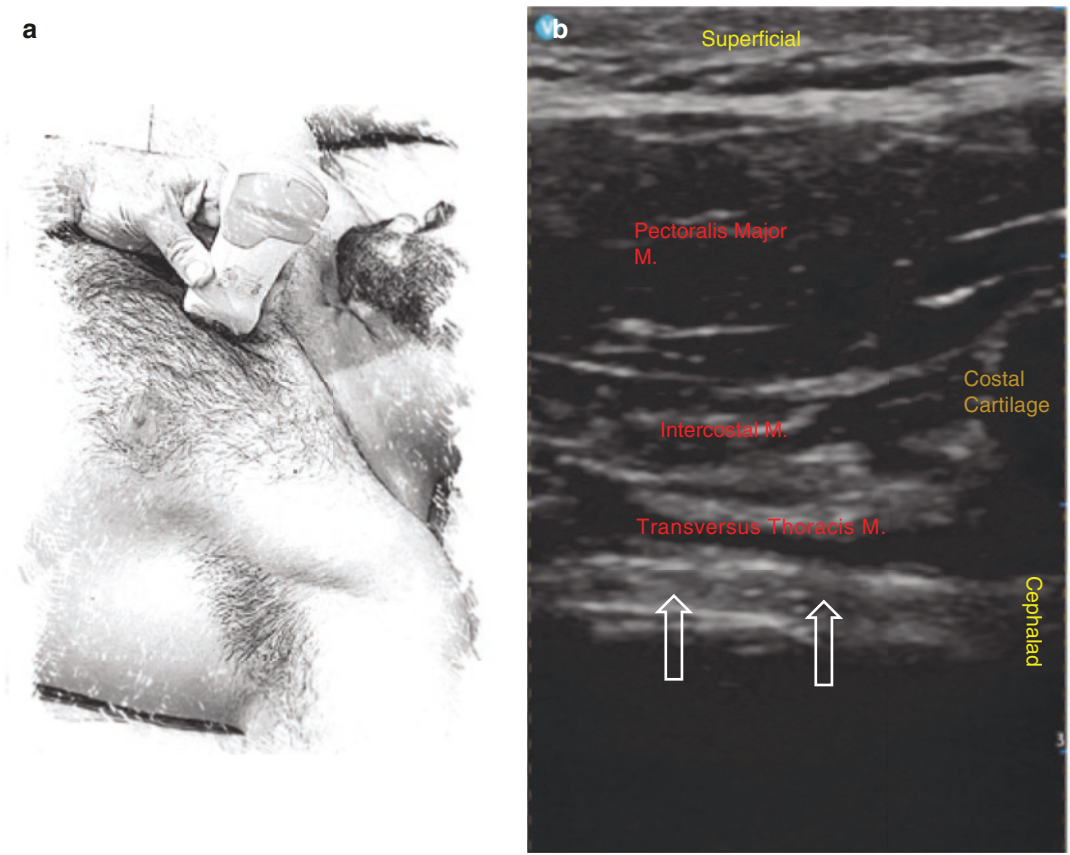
Ultrasound-guided Parasternal Intercostal Plane block. (a) Position of the probe for the PIP Blocks. Blue dot is the location of the needle approach. (b) Ultrasound image of PIP. Superficial PIP is the fascia plane between
